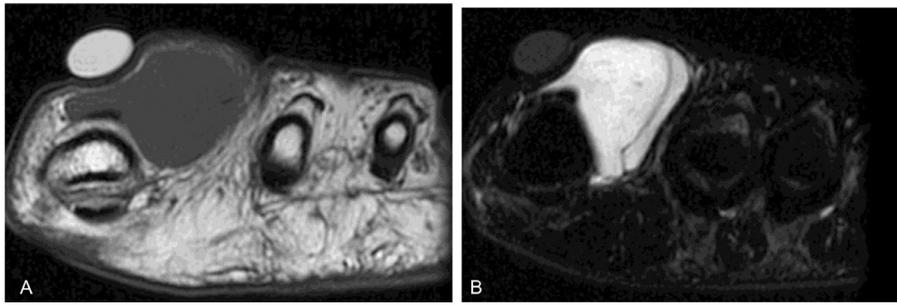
Myxoid liposarcoma. (A) Coronal short-axis T1WI shows a large, well-margined mass between the first and second proximal phalanx. The mass is iso intense to the muscle without any fatty component. (B) On coronal short-axis STIR image, the mass shows high signal intensity. STIR, short tau inversion recovery; T1WI, T1-weighted images.
